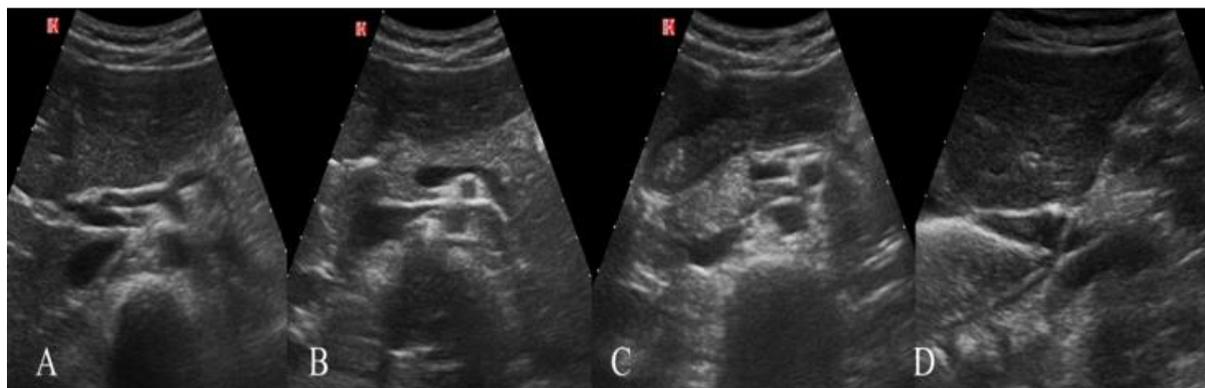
The sonographic appearance of epigastric area: A) Above of pancreas (celiac trunk and porta hepatis), B) Level of pancreas, C) Below of pancreas, and D) Sagittal view of gastro-esophageal junction.
